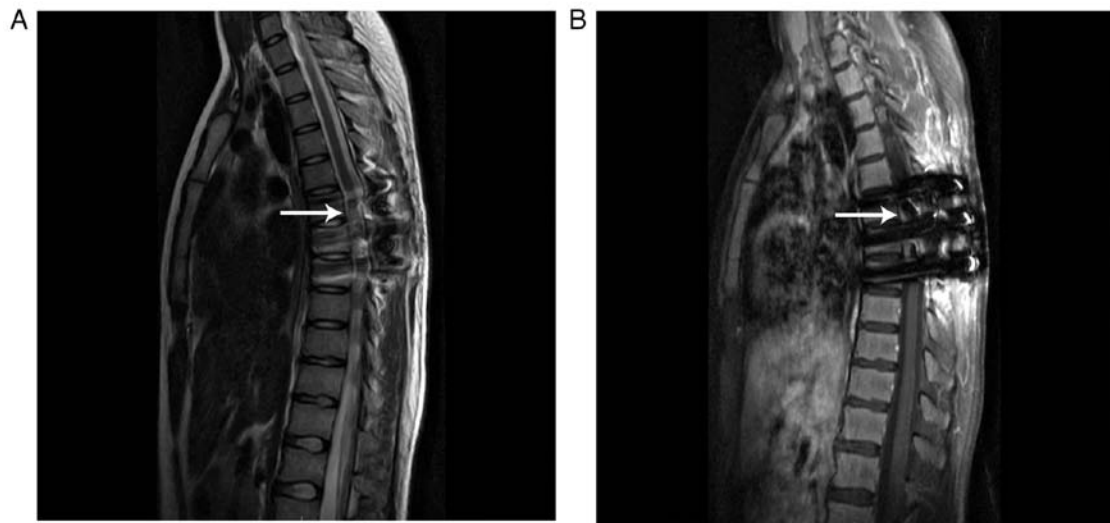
Postoperative MRI of a residual mass in the T6-8 spinal canal (white arrows). (A) T2-weighted image displaying the residual hyperintense mass. (B) T1-weighted image indicating the isointense or hypointense mass.
